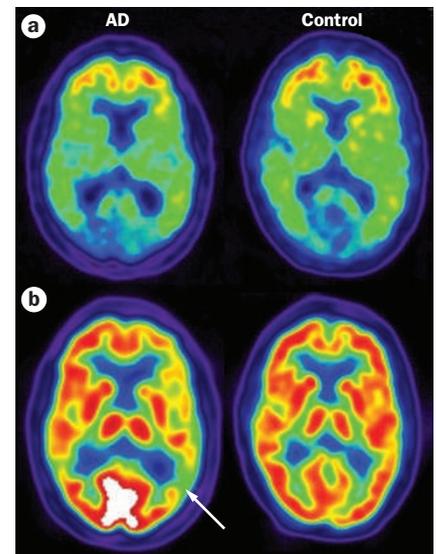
^{11}C -PIB-PET (a) and ^{18}F -FDG-PET (b) scans of a patient with Alzheimer disease (AD) and a healthy older control. The scans demonstrate equivalent fibrillar amyloid- β deposition (^{11}C -PIB scans) but a metabolic lesion in the patient with AD (arrow). Image provided by Professor William Jagust.
